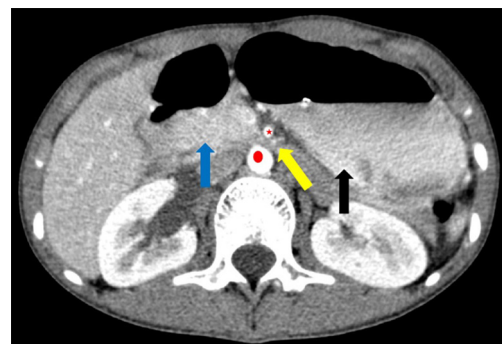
Axial view of the initial contrast-enhanced computed tomography scan of the abdomen showing a compression of the retro-mesenteric 3rd duodenal part (yellow arrow) between the abdominal aorta (red dot) and SMA (red star) with upstream distension of contrast-filled stomach (black arrow) and proximal duodenum (blue arrow). SMA, superior mesenteric artery.
